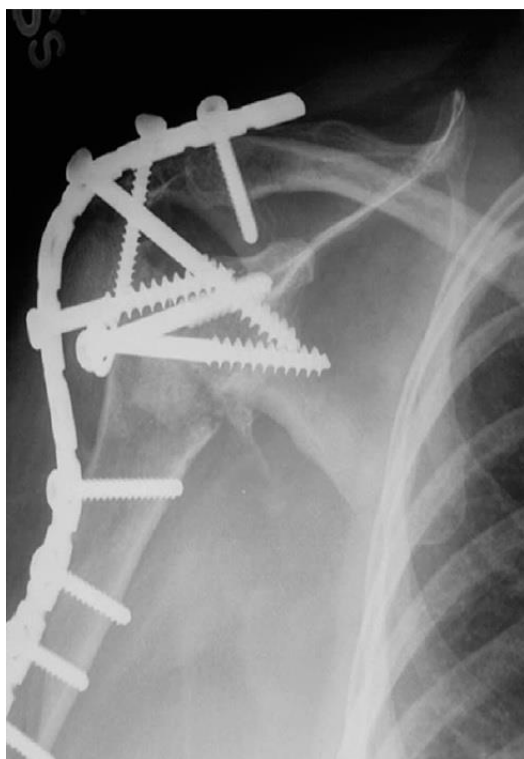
Frontal plane radiograph of shoulder arthrodesis. The purpose of the implanted construct is to prevent any motion of the humerus relative to the scapula, fixing the glenohumeral joint. Taken from Nam et al. 2010.
